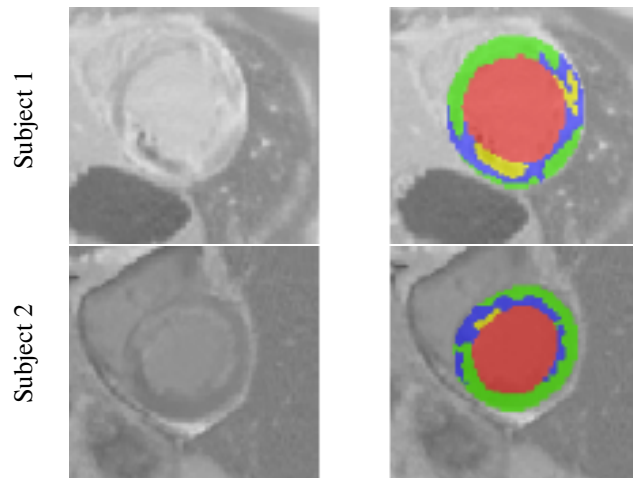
Visual examples of two slices from two different cases. From left to right: DE-MR images and annotations. In the 2nd column, the red, green, blue, and yellow colors represent the left ventricular cavity, healthy myocardium, scar, and MVO.
